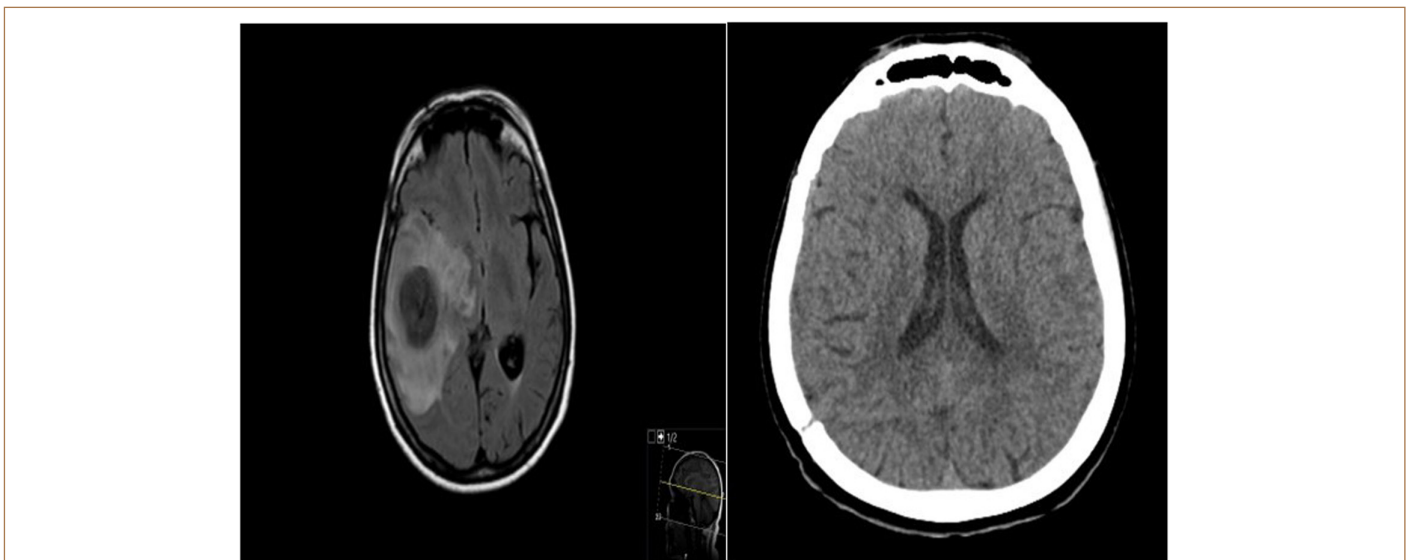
Axial (A) preoperative magnetic resonance image shows the patient with temporal lobe abscess caused by COM. Axial (B) postoperative computed tomography (CT) images of the same patient show that the abscess has disappeared.
